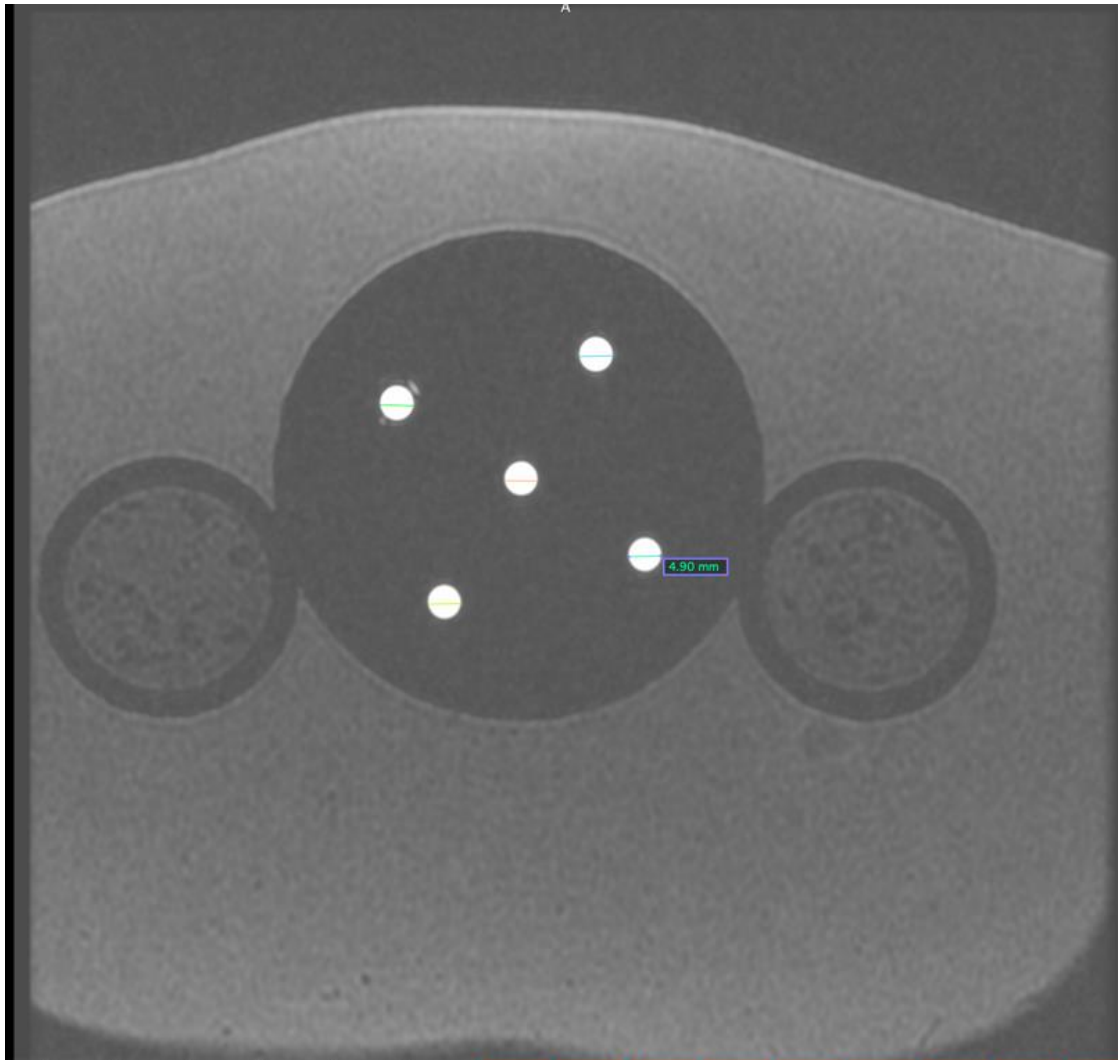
Individual lesion measurement on T2-weighted MRI
